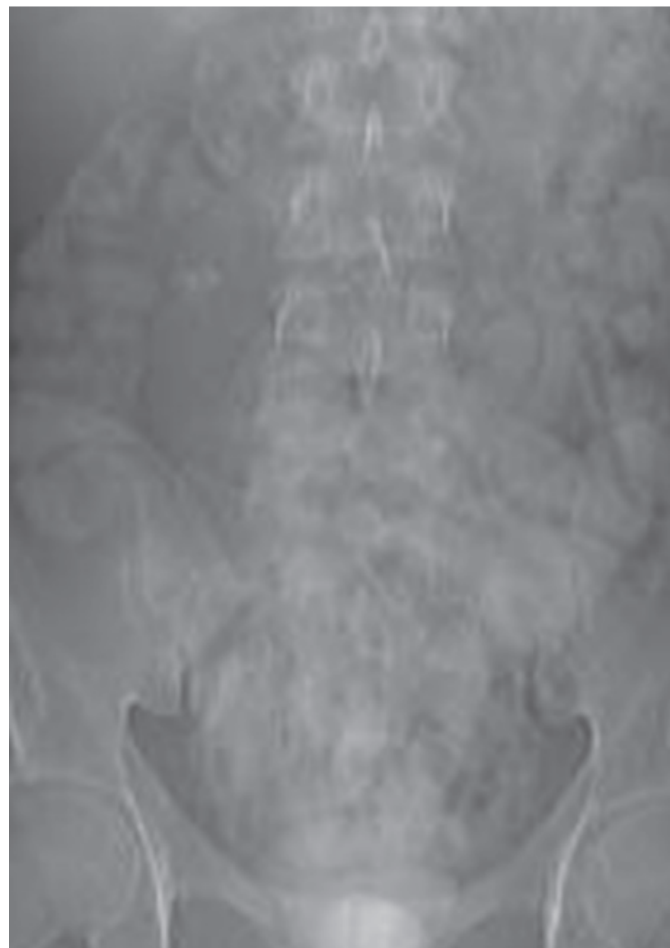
Direct abdominal plain radiography revealed a stoney structure at the right side of the vertebral column.
